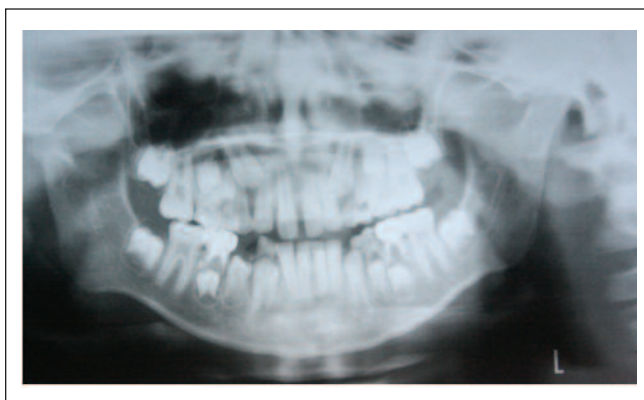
Post operative radiograph after 30 months
